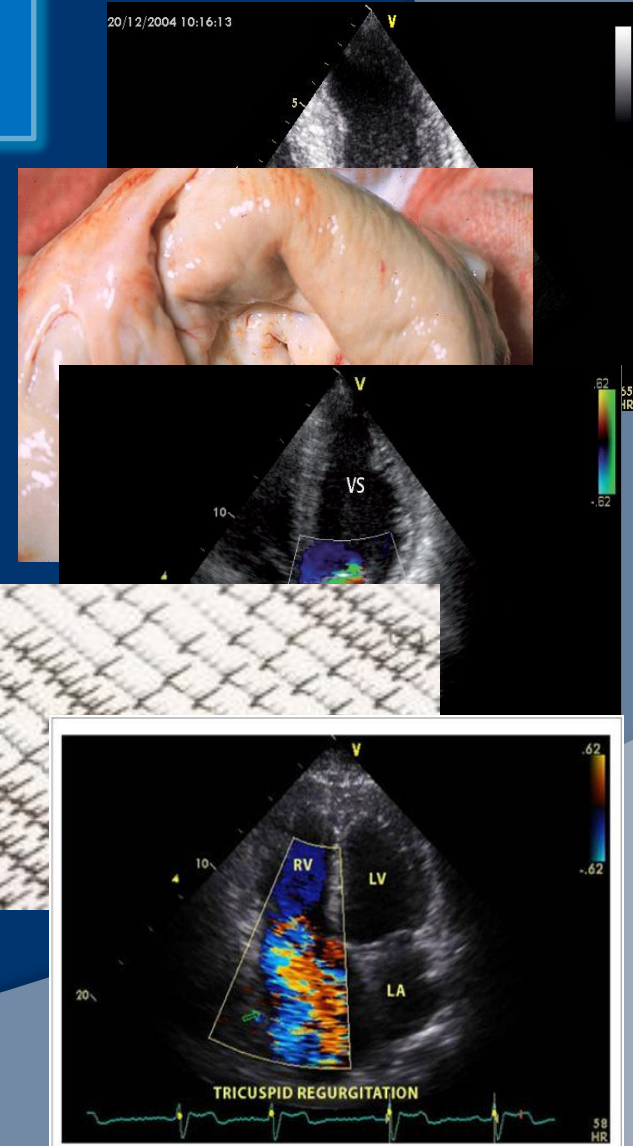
Apical 4-chamber view at the echocardiogram, showing significant tricuspid regurgitation at the color Doppler.
